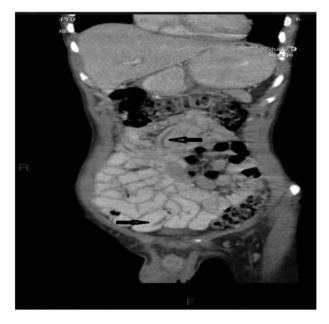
Coronal section of contrast CT of the abdomen showing tubular in the ileum and jejunal lumen.
